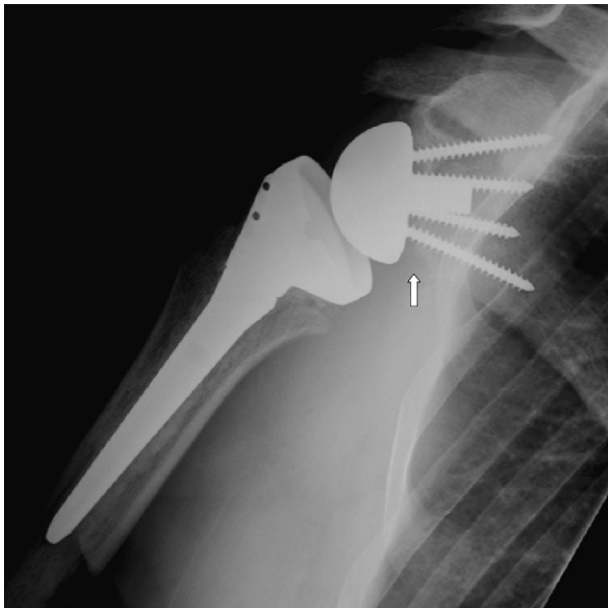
Radiograph demonstrates severe scapular notching.
